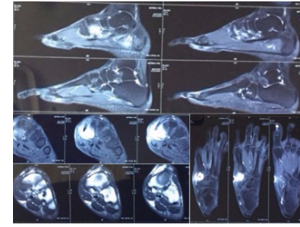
MRI of the left foot with contrast showing PD FS hyperintensity in the medial cuneiform with cortical break and surrounding bone edema
